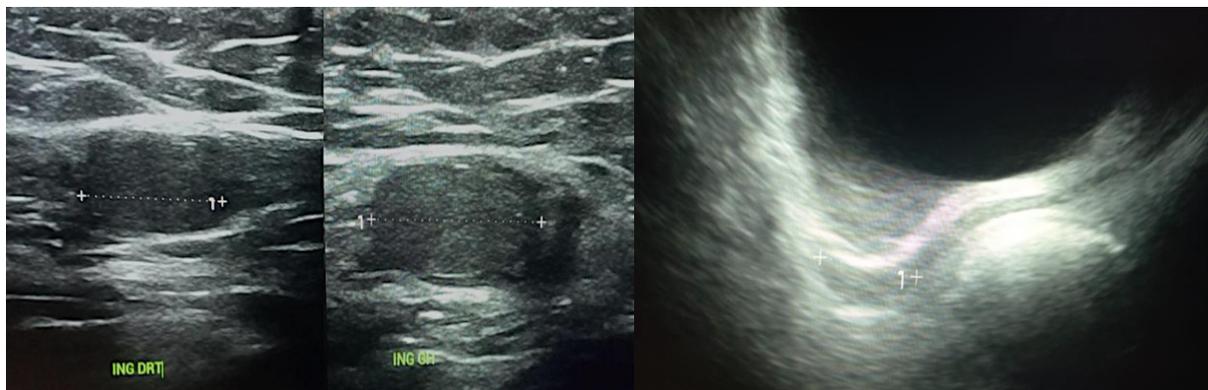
Androgen insensitivity syndrome in a 12-year-old girl with female phenotype. Abdominopelvic ultrasound shows the presence of both testicles in the inguinal canal (a) and the lower of the vagina (b)
